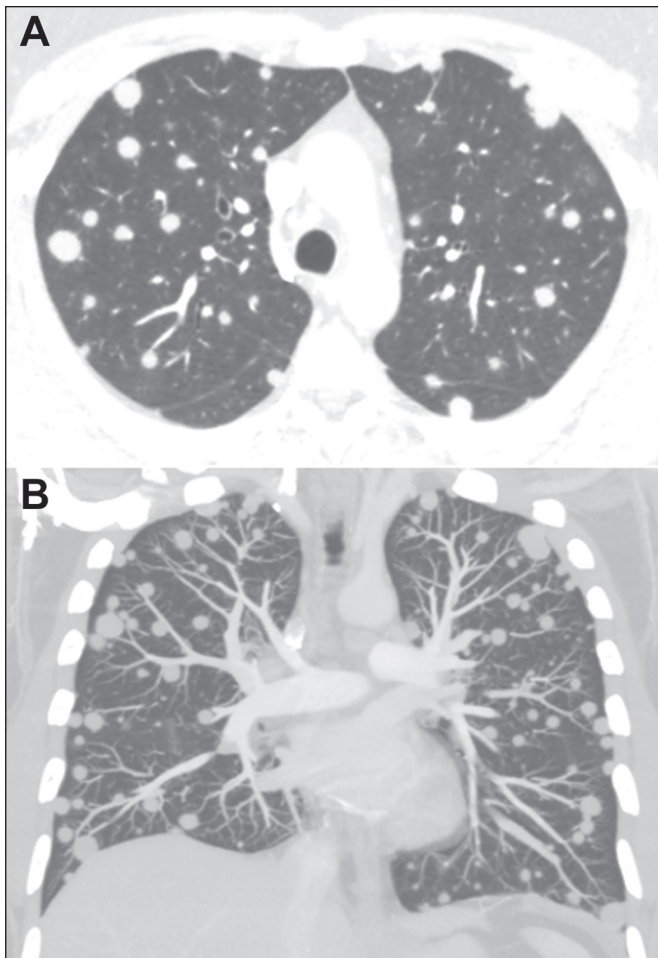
CT of a 40-year-old man diagnosed with pulmonary histoplasmosis by nodule biopsy, showing multiple nodules of varying sizes, disseminated in both lungs, mimicking hematogenous metastases.
